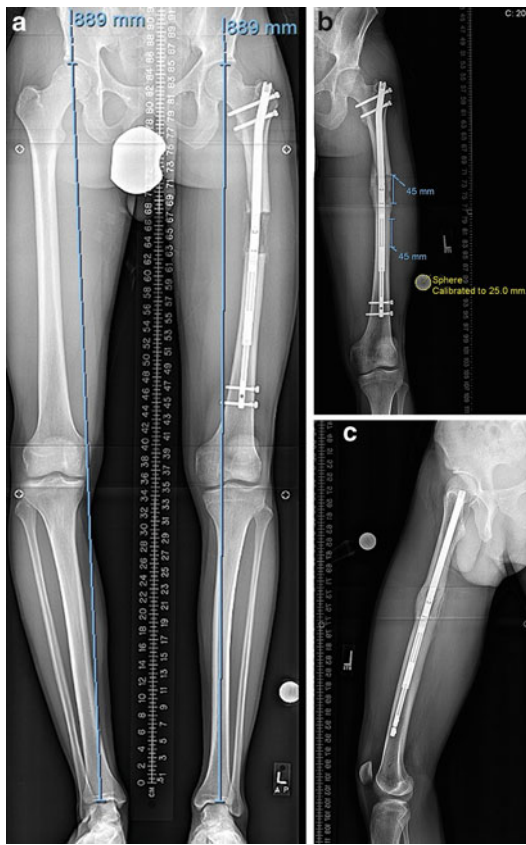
(a) Bipedal standing X-ray at the end of distraction (50 days after surgery) showing equal leg lengths. Note MAD position relative to preoperative position (Fig. 2a). Increase in valgus did not occur. (b) AP and (c) lateral X-ray of femur 4 months after surgery showing excellent bone healing progression of 4.5 cm regenerate. Note straightening of the anterior bow of the femur. Note mild varus due to proximal propagation of osteotomy on medial cortex. Full weight bearing was allowed
